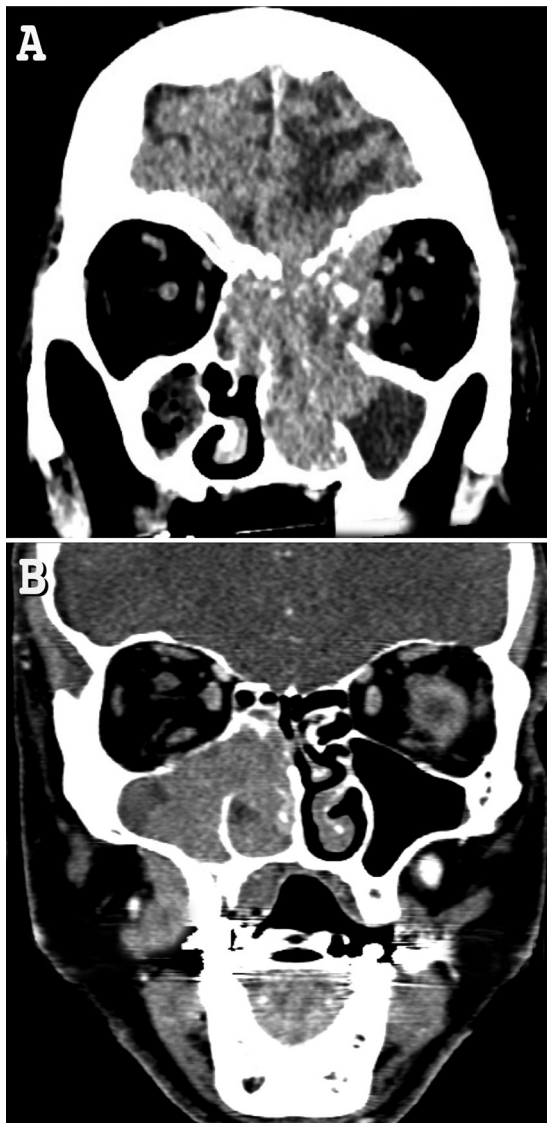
Contrast-enhanced facial bone CT-scan, coronal slice showing (A) bone lysis of the skull base and medial orbital wall by ethmoidal-maxillary tumor: Ann Arbor stage IV lymphoma; (B) malignant right maxillary sinus tumor: diffuse large B-cell lymphoma.
